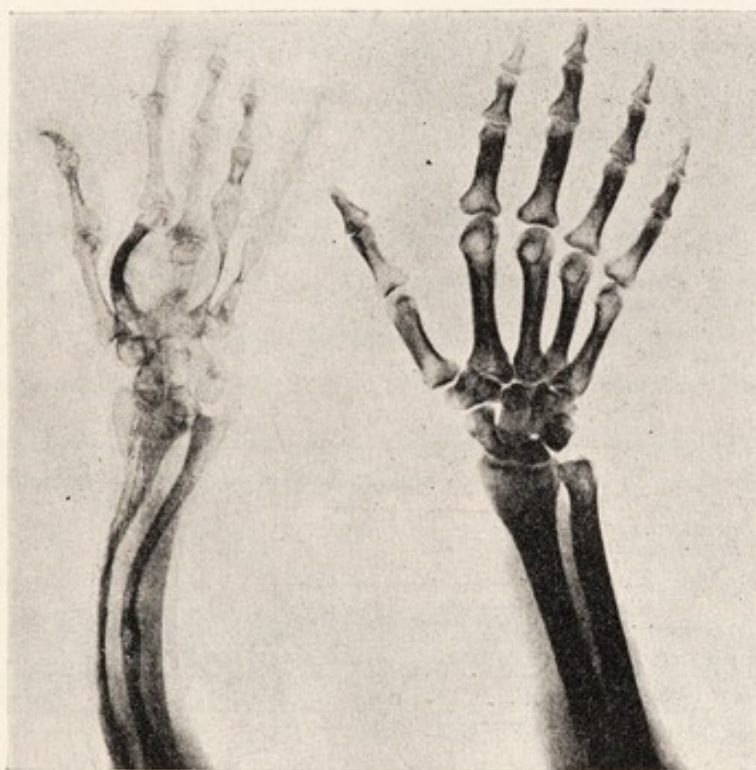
Controlled radiograph of right hand and forearm (cf. Fig. 15). (From Hunter, *Proc. Roy. Soc. Med.*, *loc. cit.*)
